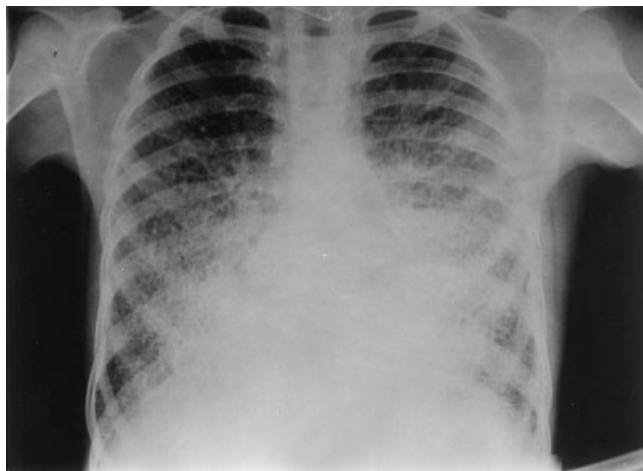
Chest X-ray of 8.5-year-old girl. Parenchyma punctiform shadows bilaterally diffuse in lungs, predominantly in the middle and lower fields, more to the center where they form modular shadows up to a few millimeters in diameter.
